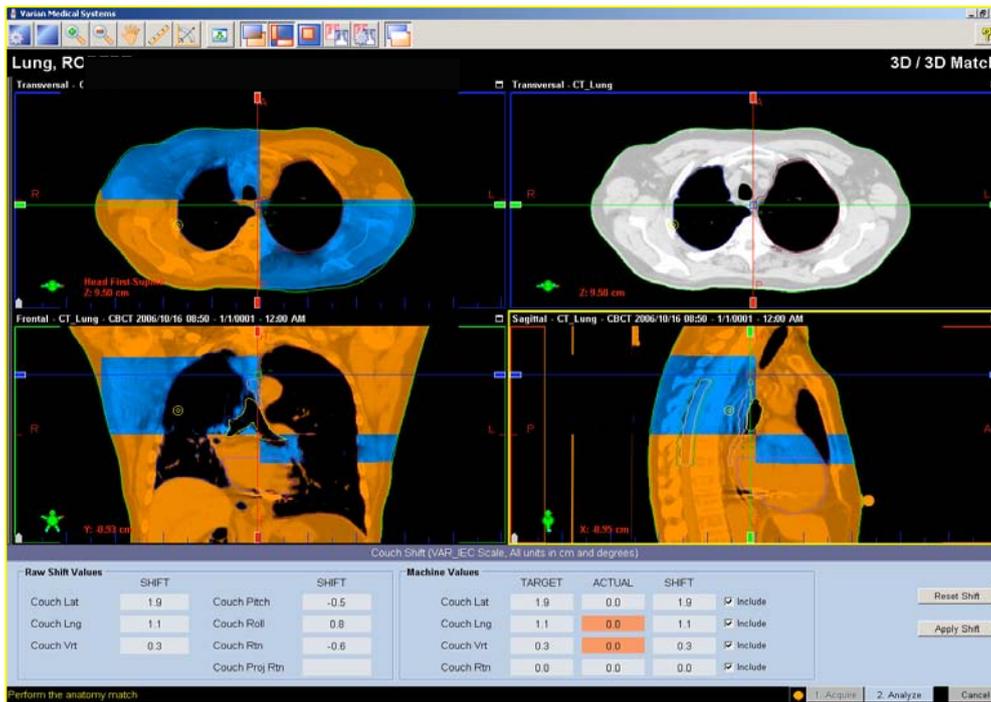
3D image registration of referenced CT and CBCT.
